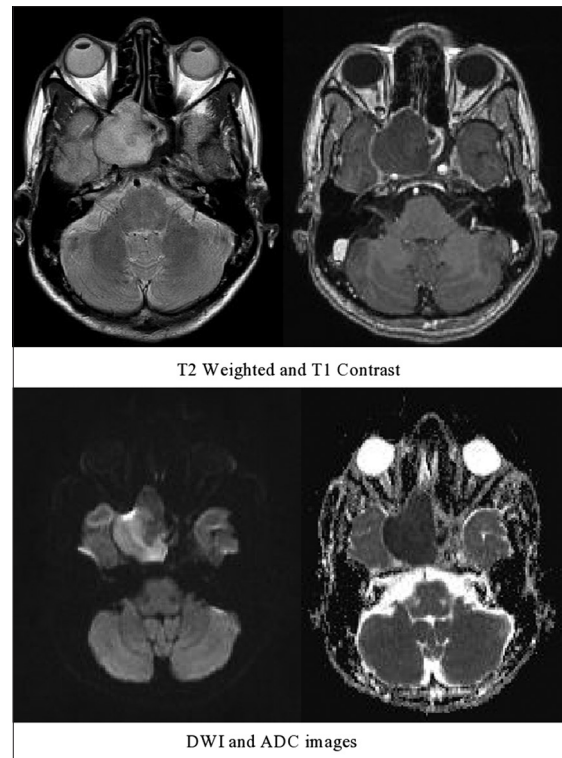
T1-weighted images contrast, T2-weighted images, diffusion-weighted imaging, and apparent diffusion coefficient mapping. 32-year-old male presents with severe headache and vomiting since 3 months. Magnetic resonance imaging shows a well-defined peripherally enhancing T2-weighted images heterogeneous signal intense lesion in the right sphenoid sinus region causing compression of right optic nerve at the apex and shows restriction on diffusion-weighted images (mean apparent diffusion coefficient of $0.444 \times 10^{-3} \text{ mm}^2/\text{s}$). Above imaging features suggestive of abscess
